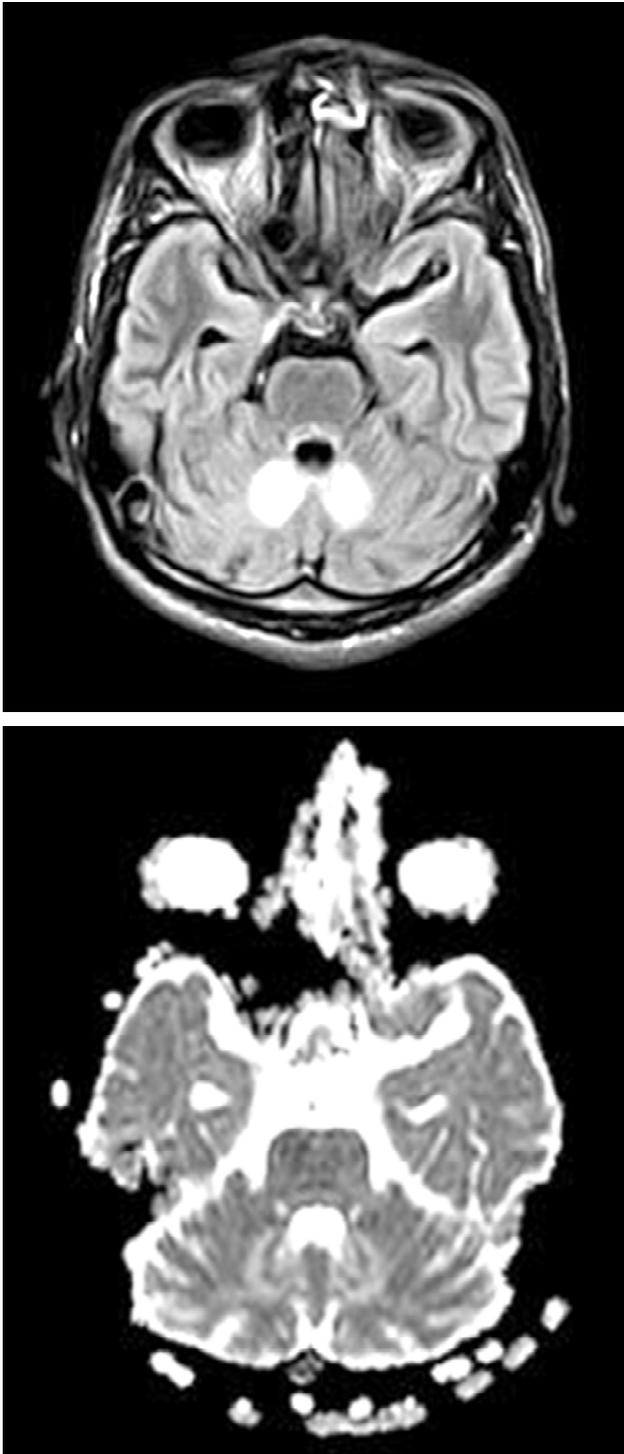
FLAIR and T2WI of MRI brain showing Hyperintense Signal intensity is noted in bilateral dentate nuclei and posterior part of pons.
